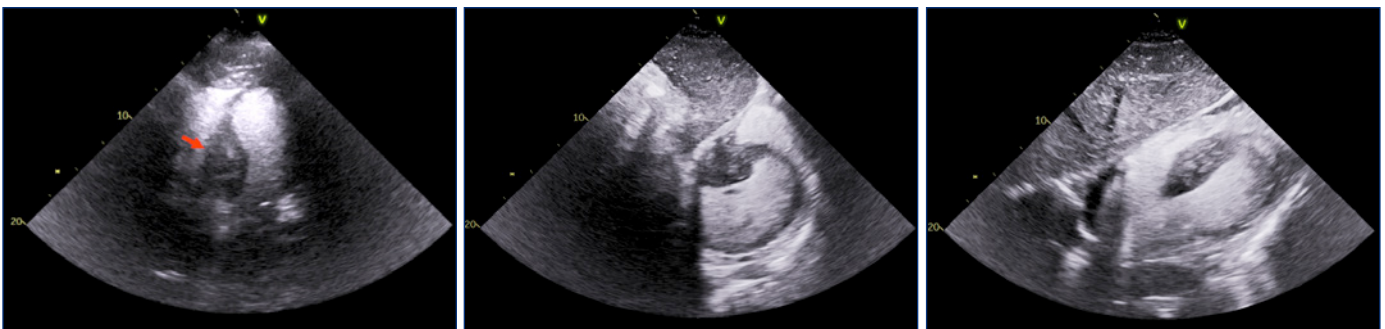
(left) Contrast enhanced echocardiogram images on apical 4-chamber view, (center) short axis view from the subcostal window, and (right) subcostal imaging (bottom panel). Red arrow denotes metastasis to the septum.
